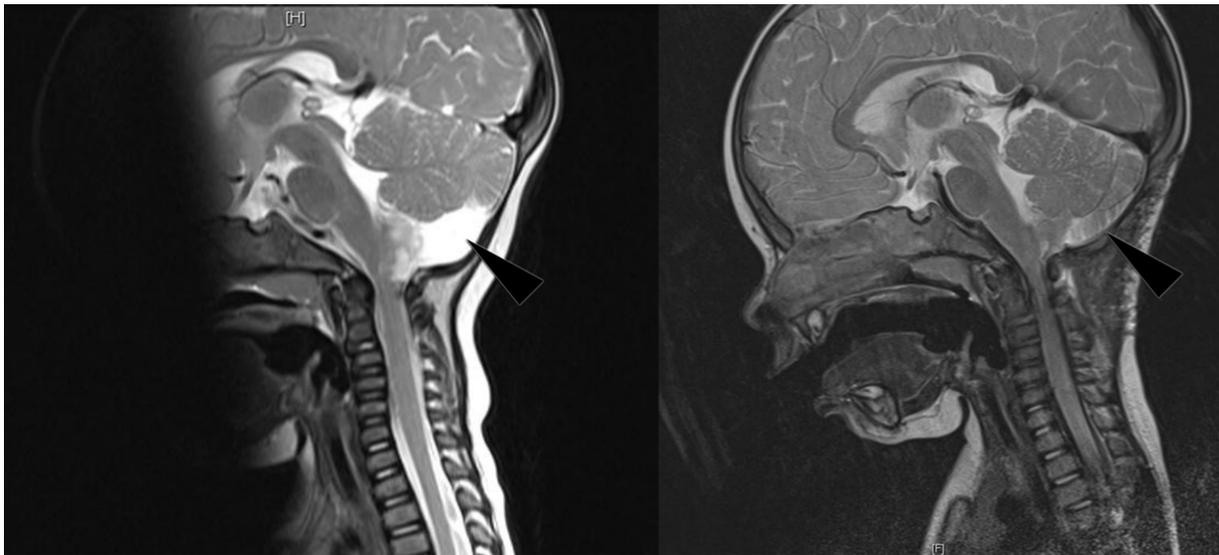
MRI before and after resection
